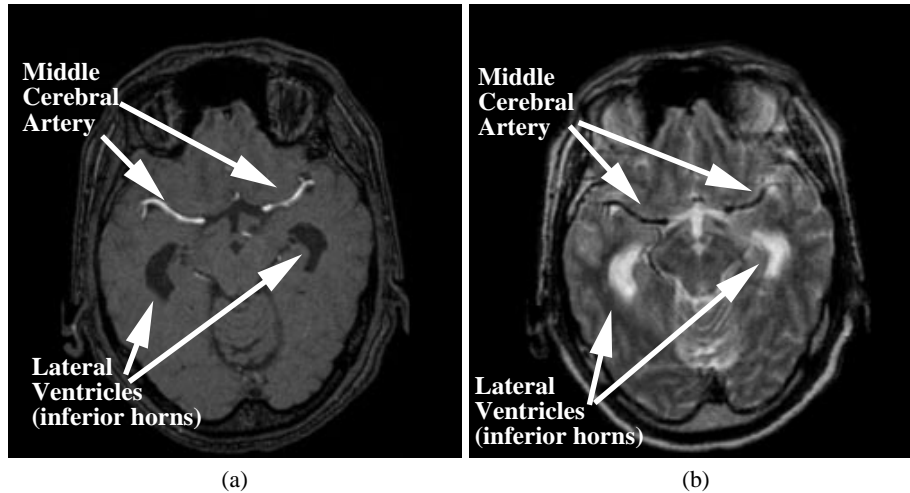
MRI axial slice with the inferior horns of the lateral ventricles and middle cerebral artery (left and right). (a) MRI Angiography sequence, (b) MRI TSE sequence.
